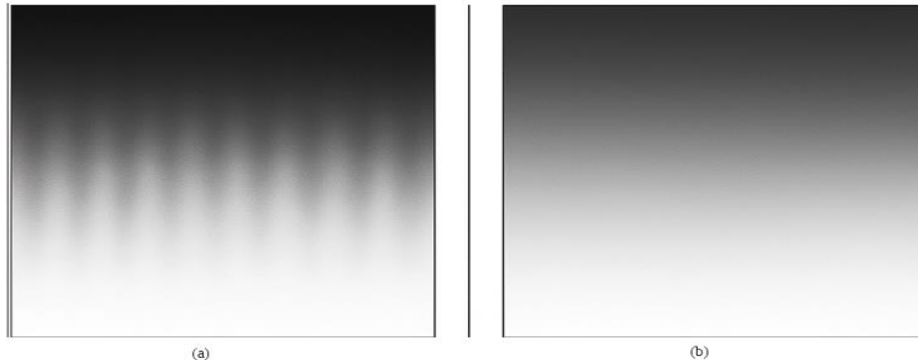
Gibbs Artefacts Suppression in MRI Image. (a) With Gibbs Artefacts. (b) After Artefacts Suppression.
